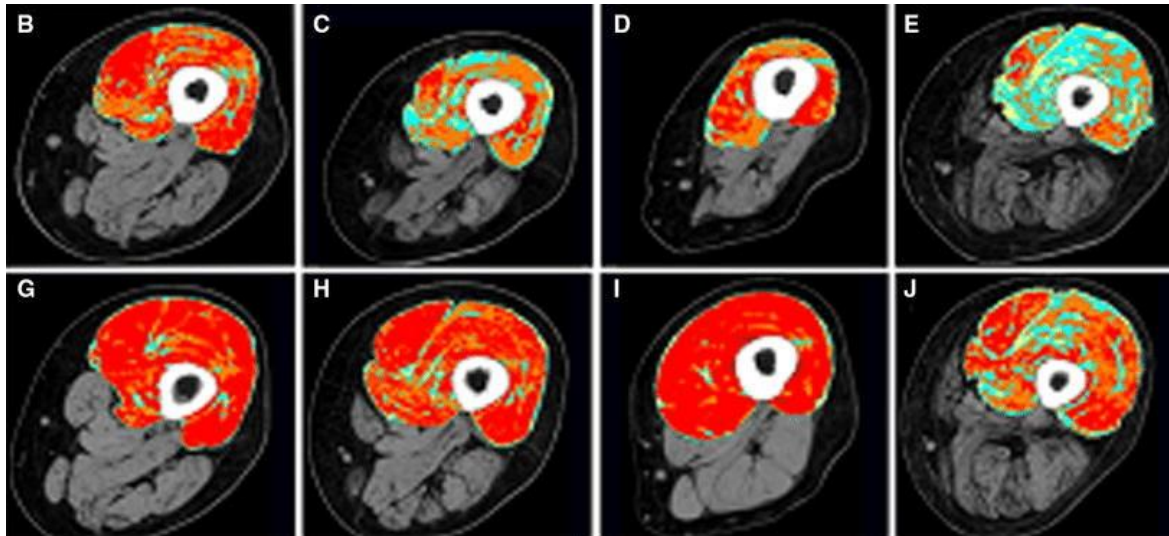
2D Color CT evidence of recovery from permanent denervation (i.e., premature muscle aging) by home-based Functional Electrical Stimulation (h-bFES). Color scans of thigh muscles before (b–e) and after 2 years (g–j) of h-bFES. Each panel Cross-sectional area and the quality of quadriceps muscles in patients starting h-bFES at different time points after denervation (b 1.2; c 1.7; d 3.2; e 5.4 years) increased after 2 years of home training (g–j, respectively). Moreover, the interstitial tissues that increased with post-denervation time (compare yellow, green and blue areas in b–e) decreased in the respective patient after 2 years of h-bFES (g–j, respectively) [47]
